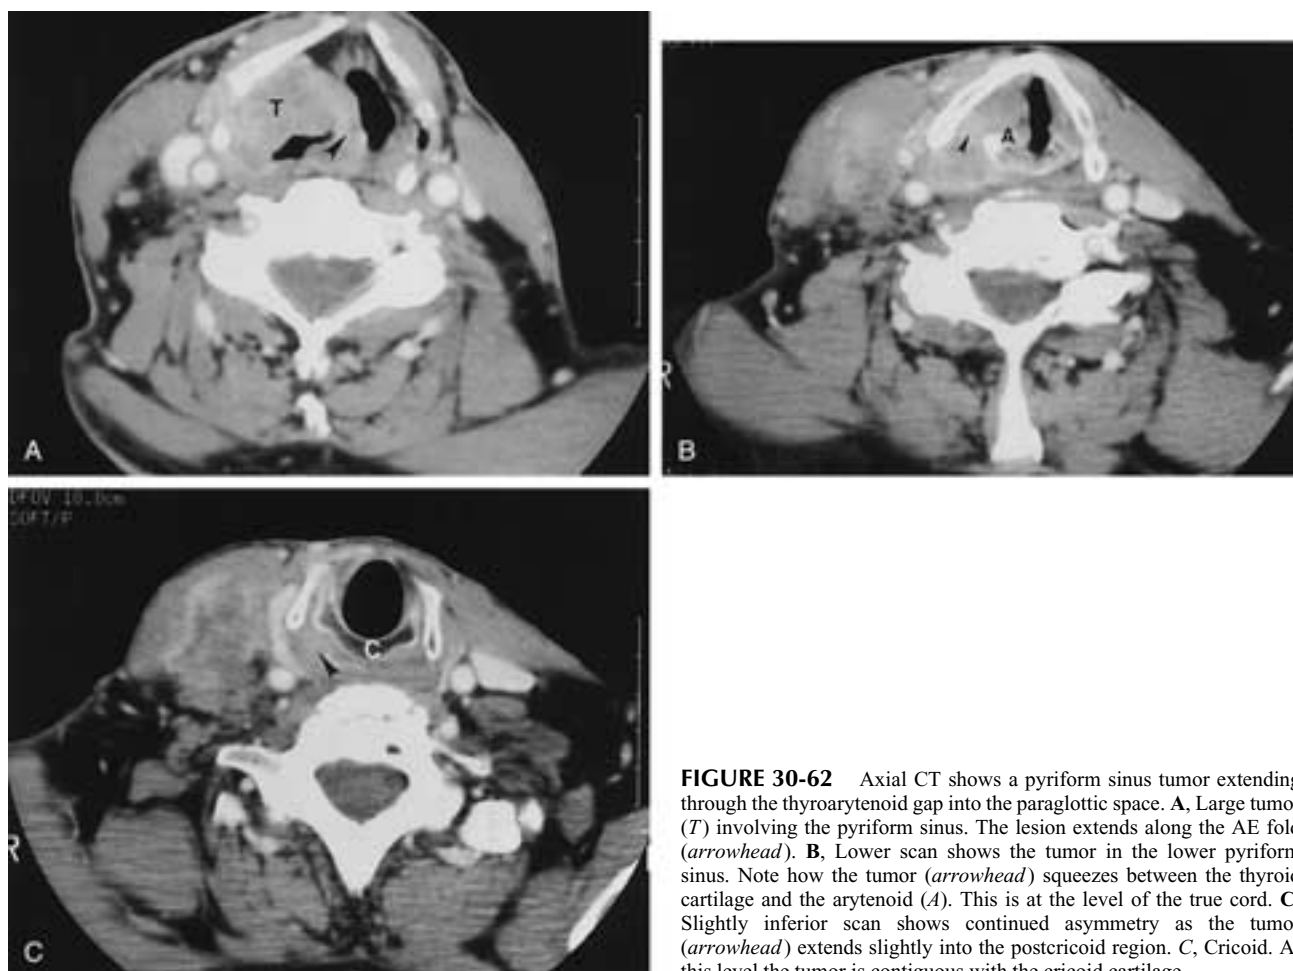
Axial CT shows a pyriform sinus tumor extending through the thyroarytenoid gap into the paraglottic space. A, Large tumor (*T*) involving the pyriform sinus. The lesion extends along the AE fold (arrowhead). B, Lower scan shows the tumor in the lower pyriform sinus. Note how the tumor (arrowhead) squeezes between the thyroid cartilage and the arytenoid (*A*). This is at the level of the true cord. C, Slightly inferior scan shows continued asymmetry as the tumor (arrowhead) extends slightly into the postcricoid region. *C*, Cricoid. At this level the tumor is contiguous with the cricoid cartilage.
